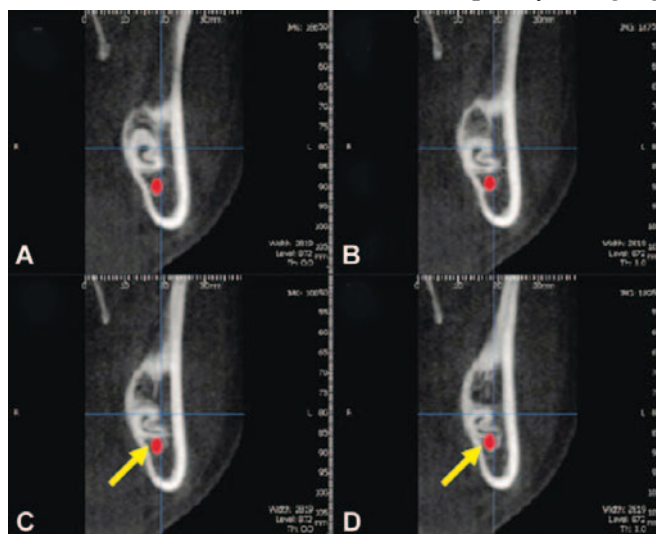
to C: CBCT images (A) horizontal, (B) parallel, and (C) cross images showing the relationship of IAN (colored and yellow arrows) to third molar roots
